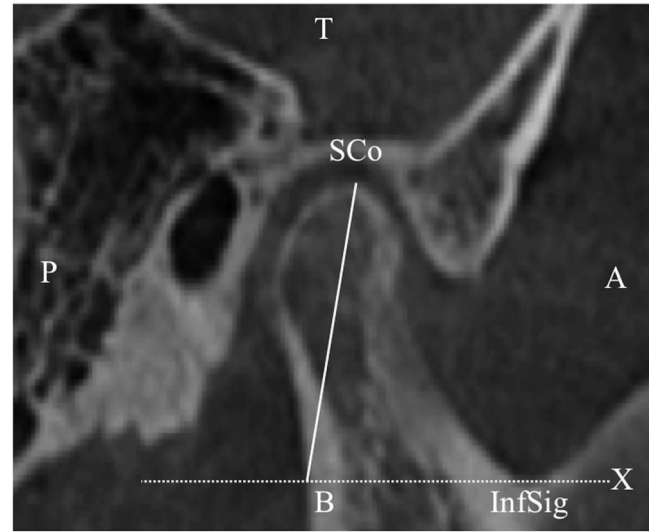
The condylar height on the sagittal CBCT image. A = anterior direction, P = posterior direction, T = top direction, B = bottom direction, SCo = the most superior condyle point, InfSig = the most inferior point of the sigmoid notch, X = tangent of the most inferior point of the sigmoid notch parallel to the true horizontal line.
